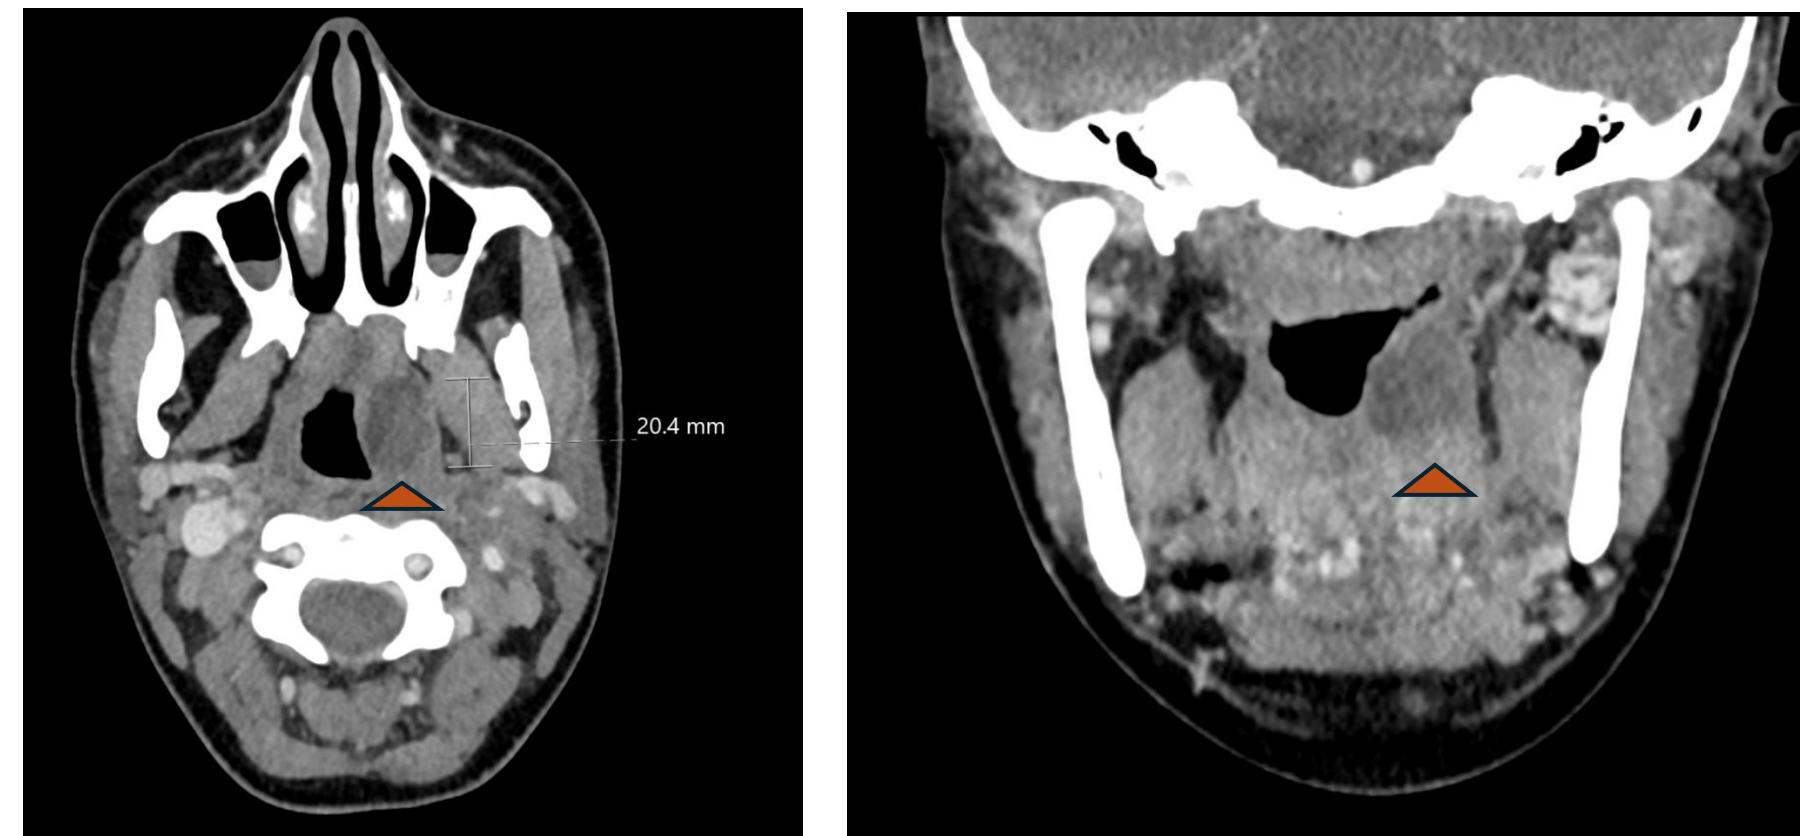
Axial (left) and coronal (right) contrast-enhanced CT neck.
